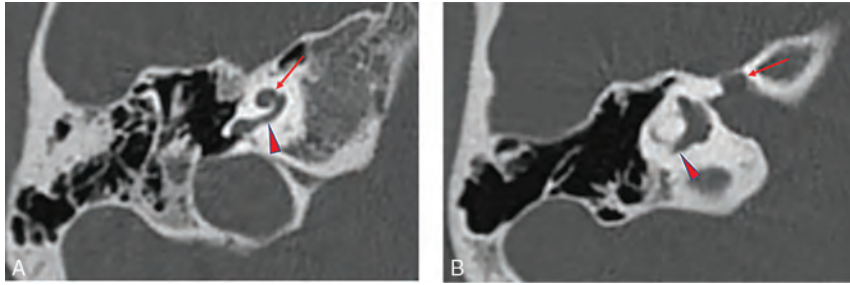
Temporal bone imaging appearance in a patient with *EYA1*-BOR. A, Axial CT image in bone algorithm shows an offset cochlea; the middle turn (arrow) is aligned more anteromedially than usual relative to the basal turn (arrowhead). The cochlea is, overall, small with a hypoplastic apical turn. B, Axial CT image in bone algorithm at a more superior level shows a medialized and widened labyrinthine facial nerve canal (arrow). The PSCC is anomalous, appearing as a blind-ending tubular structure (arrowhead).
